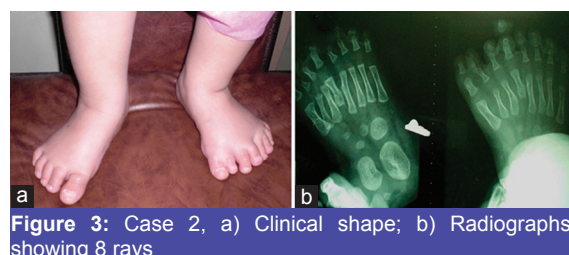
Case 2, a) Clinical shape; b) Radiographs, showing 8 rays
